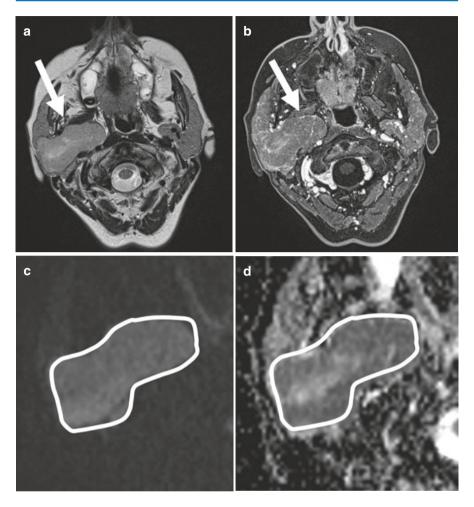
MRI examination of a huge lesion within the parotid gland that shows intermediate signal on T2W image (a) and inhomogeneous enhancement on post-contrast fat-saturated T1W image (b). The tumor shows high cellularity (and restricted diffusion) which correspond to high signal on DWI sequence (c) and low ADC value on the specific map (d)
